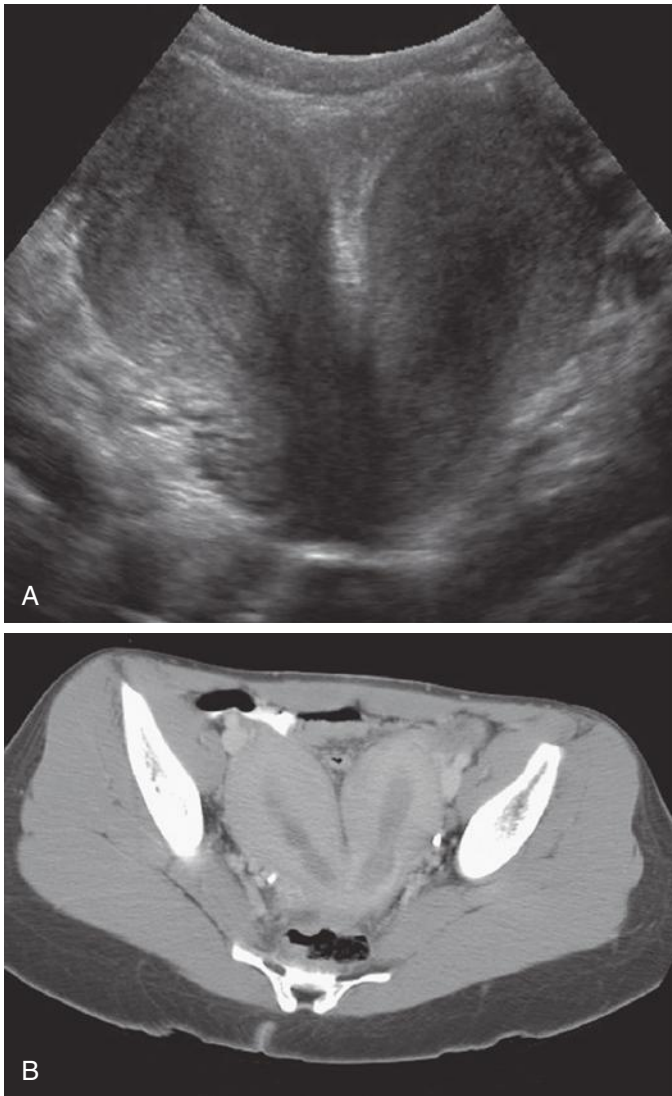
A, Coronal transvaginal view of a didelphys uterus with completely separate right and left cavities and deep intervening cleft between the two horns. B, Axial computed tomography scan of the same patient demonstrating a uterine didelphys with widely splayed uterine horns.
